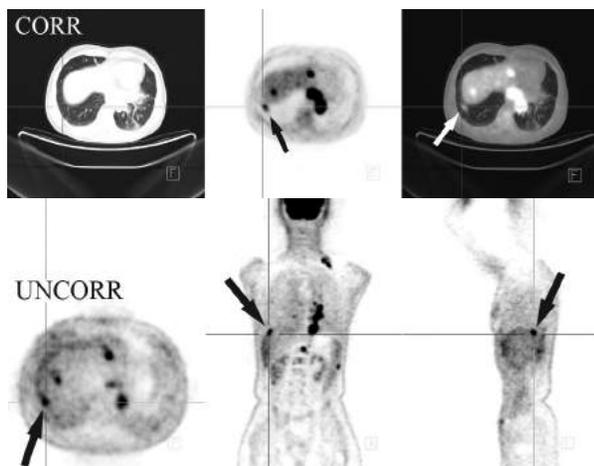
Misregistration influenced by diaphragmatic motion; hypermetabolic foci in the liver dome appear to be located in the lung base. PET and corrected image in transversal plane (arrow), PET and fused PET/CT images (arrows); Uncorrected PET images; transversal, coronal and sagittal planes (arrows)
